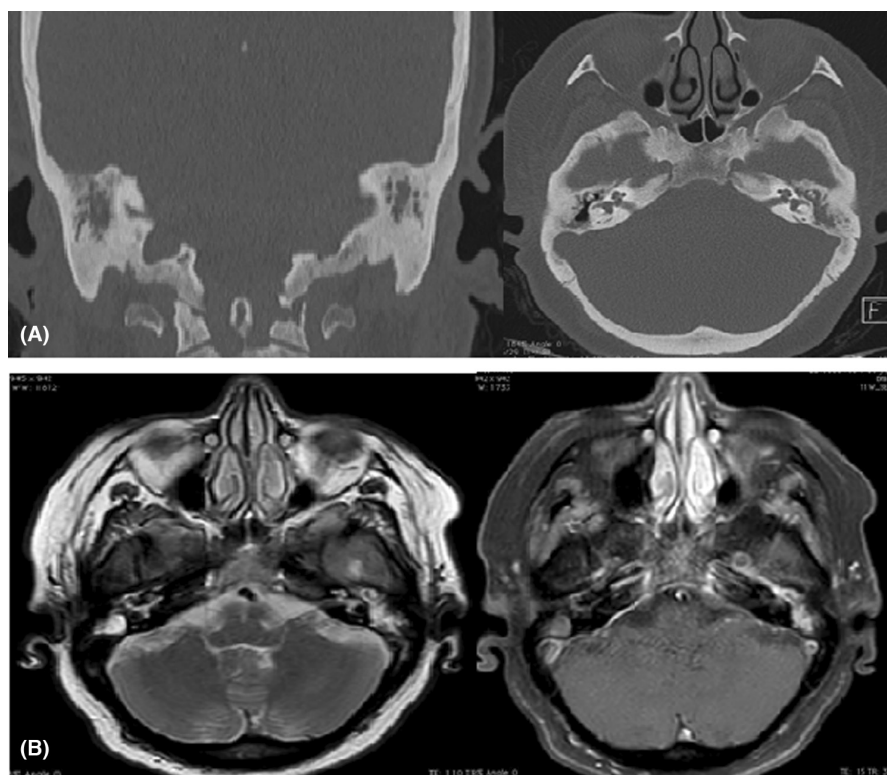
Evidence of skull base osteomyelitis in CT and MRI: A: coronal and axial CT Scan, decreased pneumatization of mastoid air cells and Bilateral petrous and clival sclerosis indicating otomastoiditis. B: T2-weighted axial MRI, Edema and effusion is noted in left middle ear and bilateral mastoid air cells with enhancement after iv contrast
